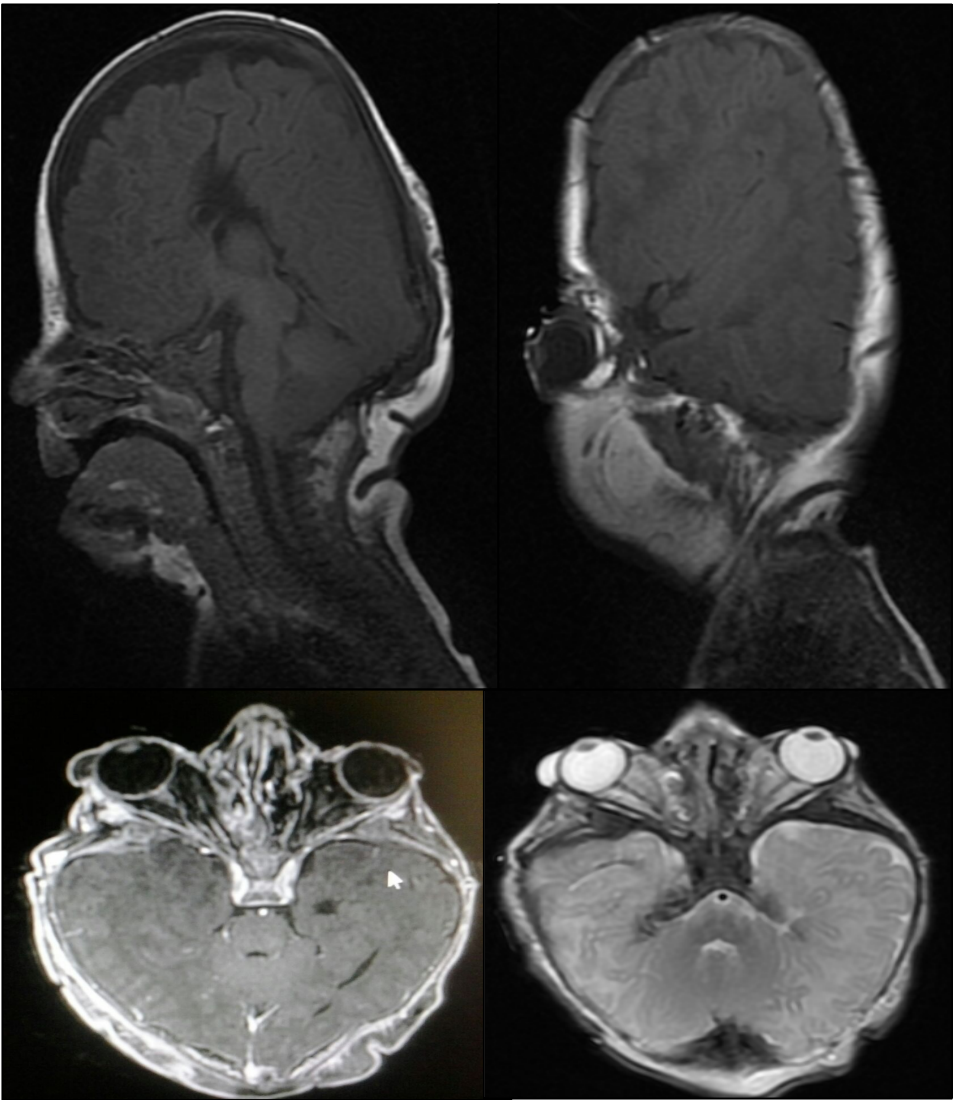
Turribrachycephalic shape and ocular proptosis on MRI
